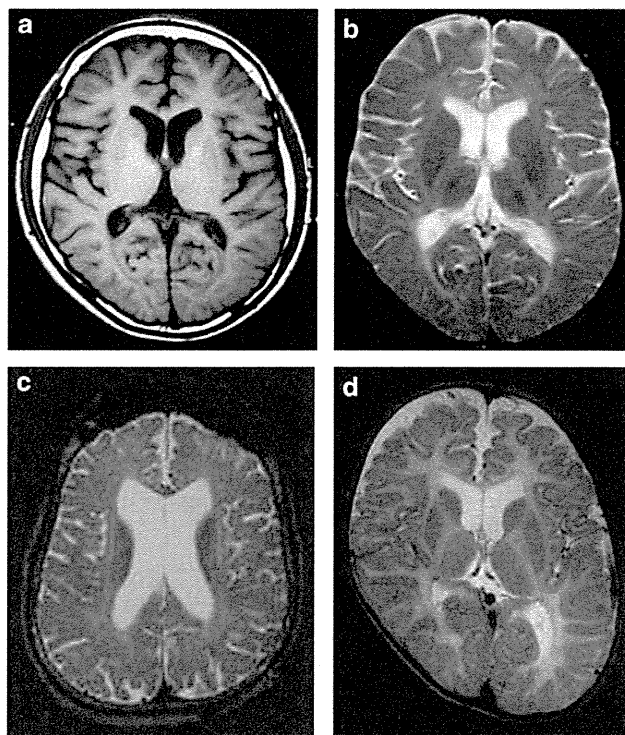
Brain MRI findings of the patients T1- (a) and T2 (b) weighted images of Patient 1 show mild and diffuse volume loss of the brain and high-intensity signals of the deep white matter in T2 indicating mild dysmyelination. T2-weighted image of Patient 2 (c) shows diffuse volume loss resulting in the dilatation of the ventricles and dysmyelination in the white matter. T2-weighted image of Patient 3 (d) shows extremely hypomyelinated pattern with high intensity in all white matter.
